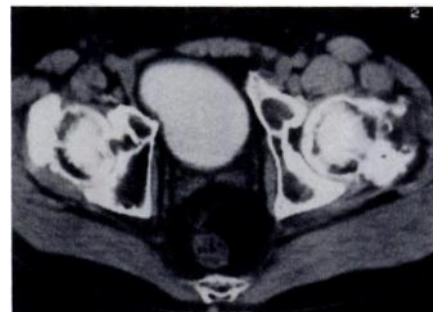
CT scan at the level of the urinary bladder 1 hour after injection of Gd-DTPA. The bladder, because of renal excretion, is filled with concentrated Gd-DTPA. This results in a high attenuation of the bladder lumen. No iodinated contrast agent was used. Note the multiple exostoses.
